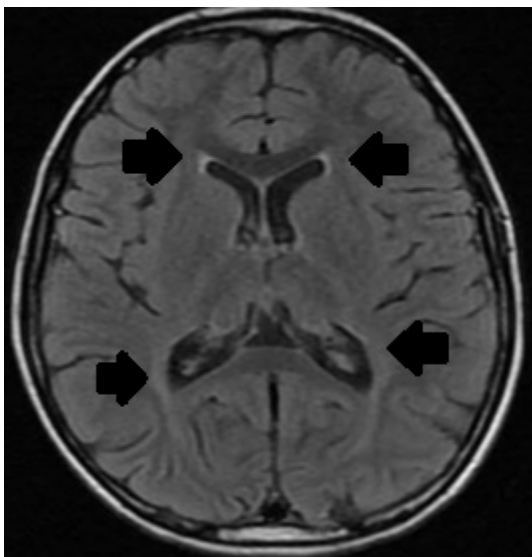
FLAIR Axial Section: Bilateral Hyperintensity in the Periventricular White Matter (black arrows).
